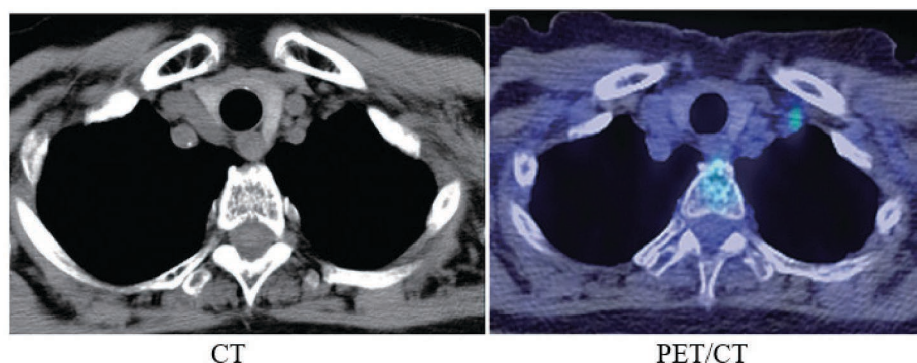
A case in which no metastasis was found on CT, but metastasis was found in the left supraclavicular lymph node by PET/CT. This case underwent lymph node biopsy and was pathologically diagnosed as metastasis of urothelial carcinoma.
